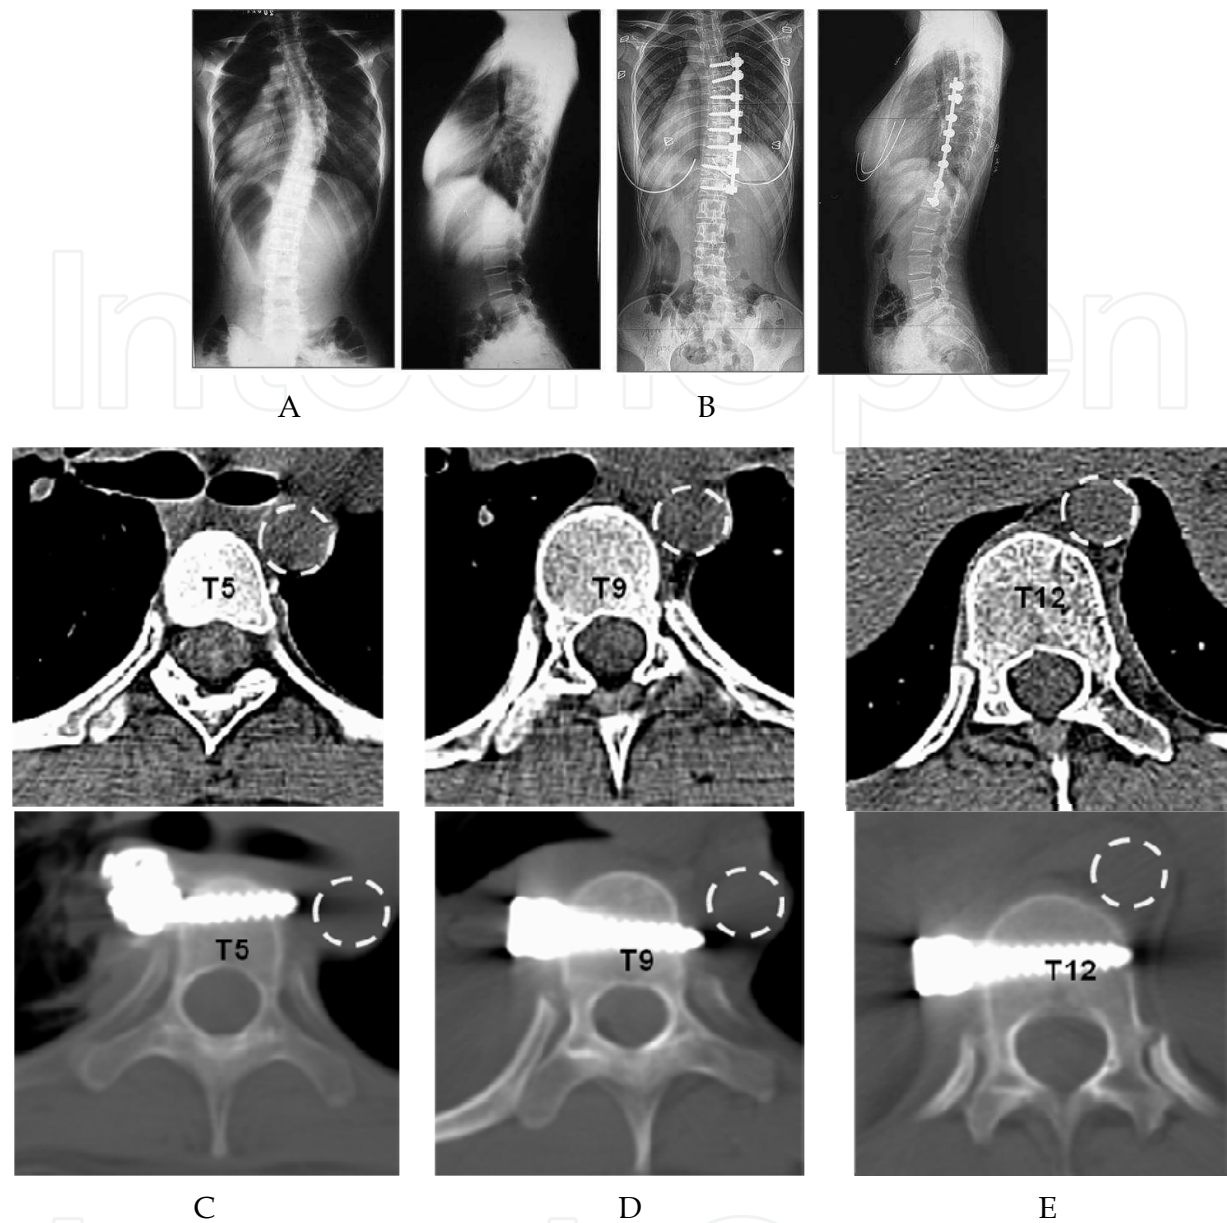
A 17-year-old girl with IS Lenke Type 1A- was operated by mini-open thoracotomic anterior approach. A: Pre-op anteroposterior and lateral X-ray, Cobb angle 40°; B: Post-operative anteroposterior and lateral X-ray show the Cobb angle corrected to 10°; pre and post-op CT images of T5 (C), T9 (D), T12 (E), the aorta shift posterolaterally after curve correction.
